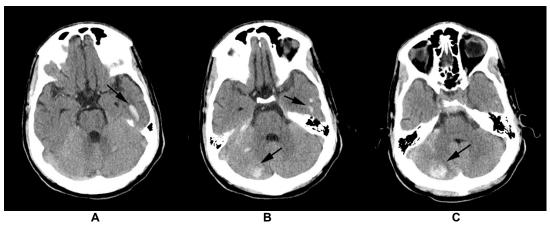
Figure A, B and C. Non contrast CT head demonstrating left temporal and right cerebellar hemorrhages.
